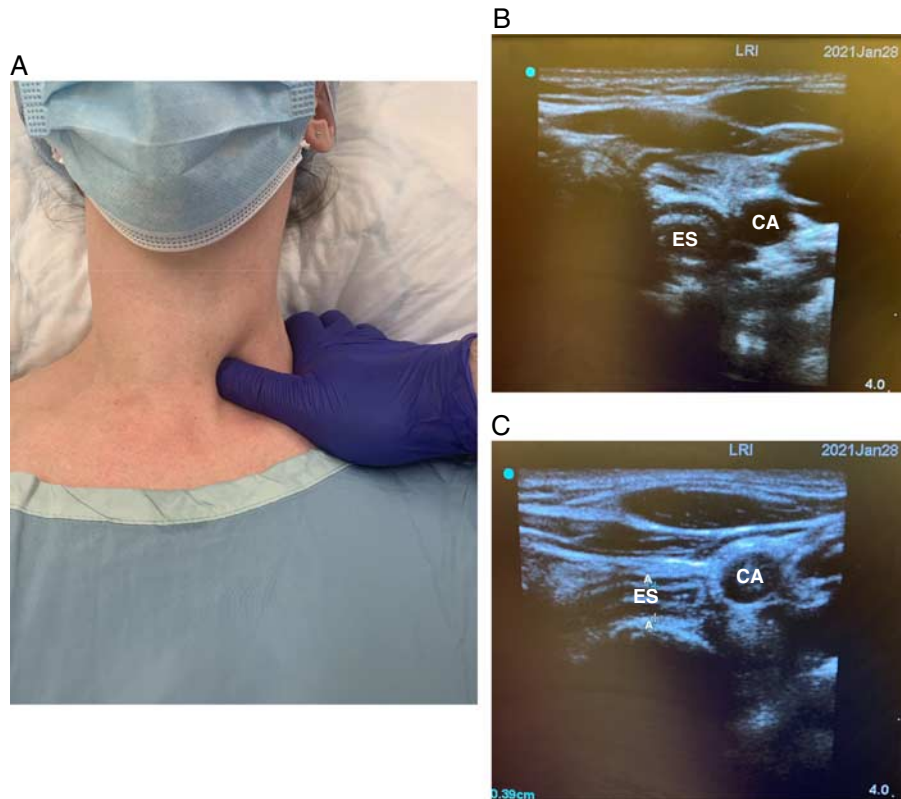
Application of low left paratracheal pressure (A) on the esophagus (as described by Gautier et al⁹³). Ultrasound images demonstrating the esophagus (B) and compression of the esophagus (C) by applying pressure with the probe in the transverse plane, just cephalad to the suprasternal notch. CA indicates carotid artery; ES, esophagus. [full color online](#)
